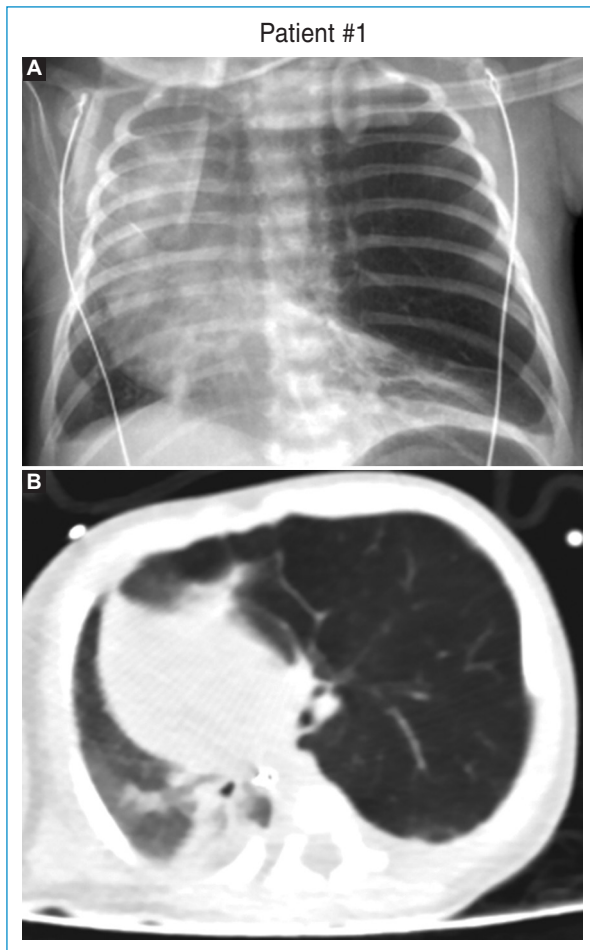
A: chest X-ray: hyperlucent LUL, mediastinum shift and atelectasis. B: CT scan: large-volume CLE, pushing the mediastinum to the opposite side.
